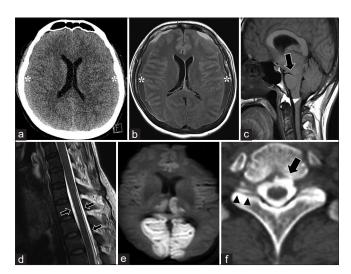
Case 1. (a, b) A brain computed tomography and magnetic resonance imaging showed a subdural hemorrhage (asterisks). (c) A T1-weighted brain magnetic resonance imaging showed descended cerebellar tonsils (arrowhead) with a decreased mamillo-pontine distance (arrow). (d) T2-weighted cervical magnetic resonance imaging showed diffuse dorsal extradural fluid (arrows). (e) Diffusion-weighted magnetic resonance imaging demonstrated acute infarctions in both posterior cerebellar artery territories. (f) Postmyelography computed tomography showed cerebrospinal fluid leakage into the ventral epidural space (arrow) and contrast leakage through the nerve root (arrowheads)
